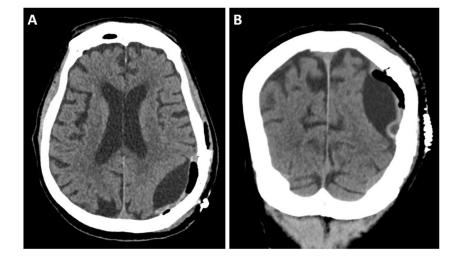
Unenhanced CT of the head, showing axial (A) and coronal (B) images, demonstrates immediate postoperative changes following left parietal craniotomy and chronic subdural hematoma evacuation. There is expected small postoperative pneumocephalus and fluid within the resection cavity.
